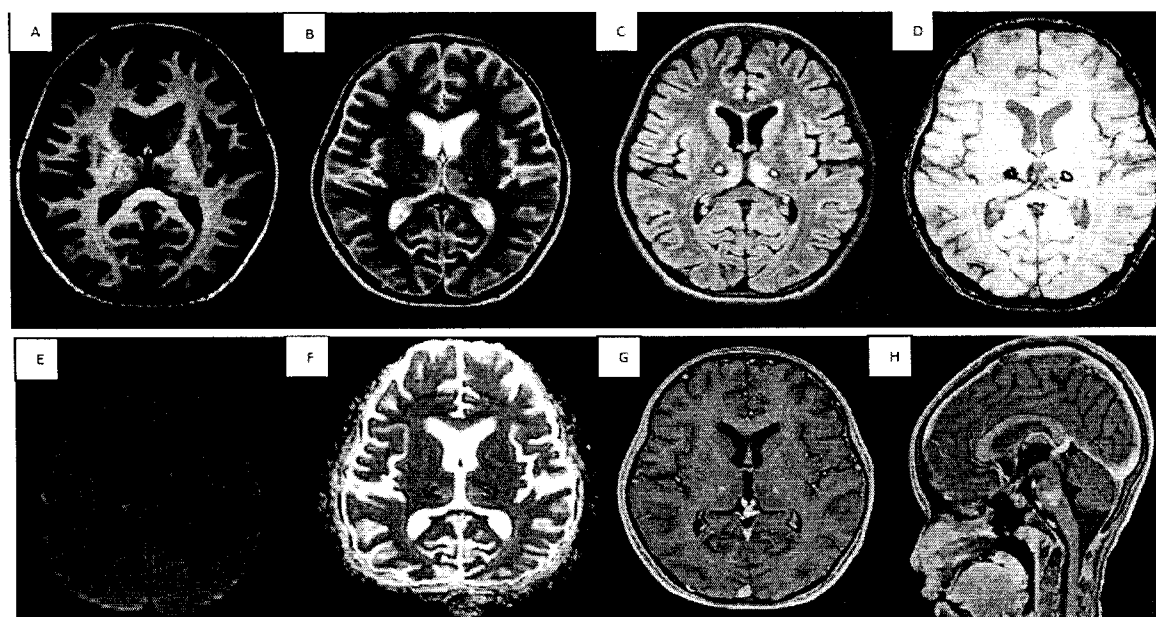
Contrast enhanced MRI brain performed at 4th week of illness (A, B, C,D) showed lesions in both thalami which were hyperintense on T1WI (A), hyperintense lesion with hypointense rim on T2WI(B) and FLAIR(C) . SWI image (D) demonstrated signal drop due to blooming effect, suggestive of hemorrhage. Intense restricted diffusion was seen on DWI and ADC map (E,F). T1 contrast showed no evidence of cerebral venous sinus thrombosis (G,H)
